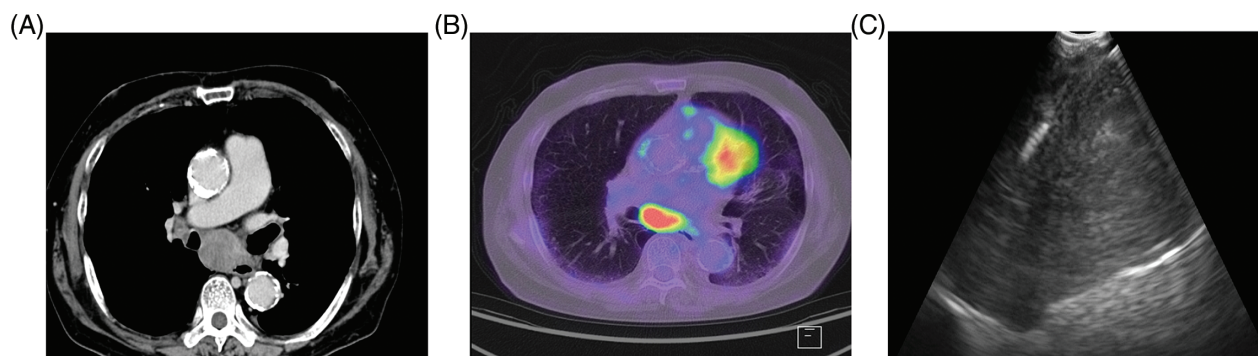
(A) Chest computed tomography revealed mediastinal lymphadenopathy measuring 30 mm in the shortest diameter. (B) Fluorodeoxyglucose positron emission tomography showed a hypermetabolic lesion in the enlarged mediastinal lymph node. (C) An ultrasound image of the puncture procedure showed the needle within the mediastinal lesion.
